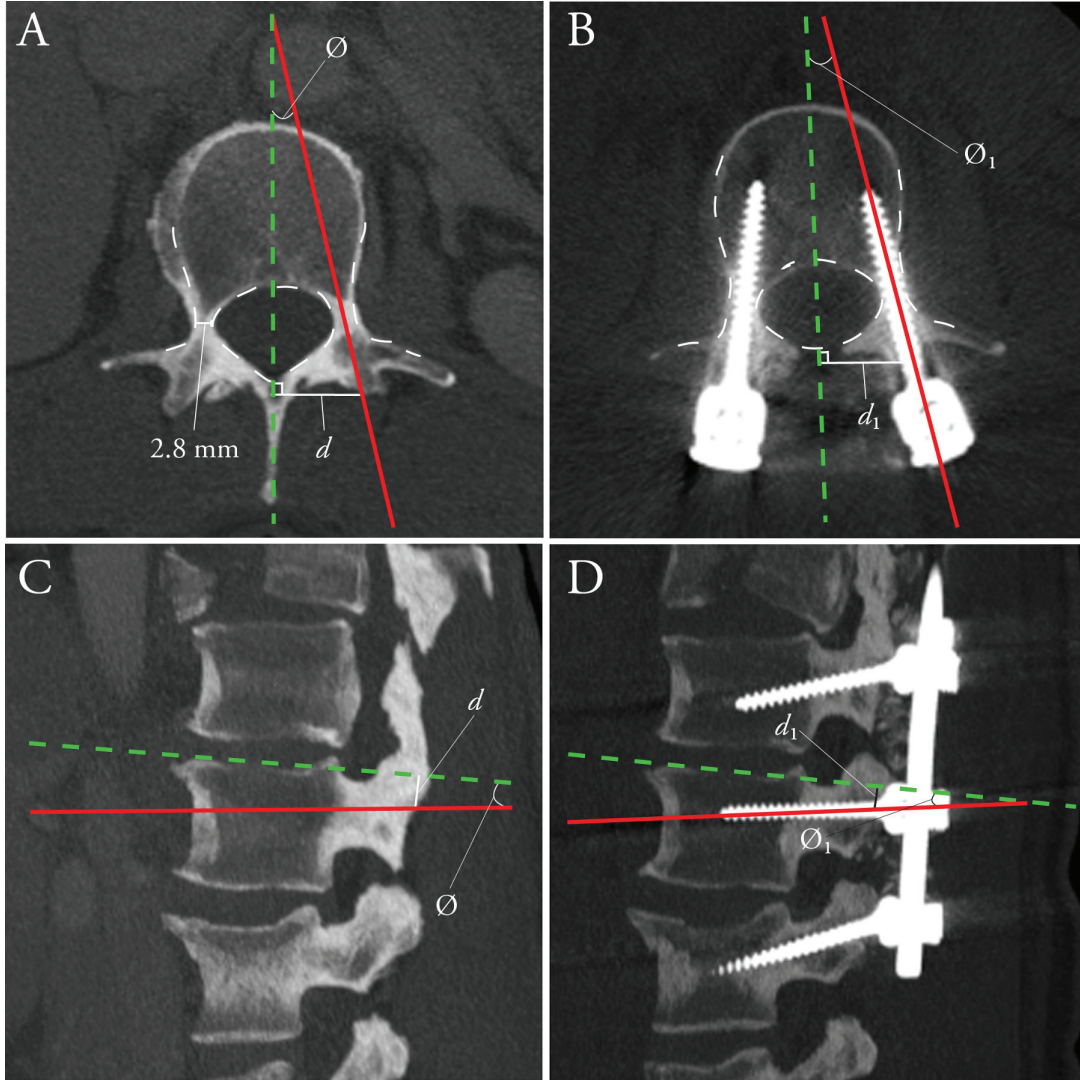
Engineering analysis quantifying absolute translational and angular deviation in the axial and sagittal planes. Example shown of a patient with hypoplastic pedicles at L2. A) Intraoperative predicted screw trajectory (red) as visualized on a pre-operative axial CT. B) Post-operative actual screw trajectory (red) as visualized on a multiplanar reformatted post-operative CT. Axial distances ( $d$ ) were measured at  $90^\circ$  relative to midsagittal axis (green line). Angle ( $\phi$ ) represents corresponding trajectory angles. C) Intraoperative predicted screw trajectory (red) as visualized on a pre-operative sagittal CT. D) Post-operative actual screw trajectory (red) as visualized on a multiplanar reformatted post-operative CT. Sagittal distances ( $d$ ) were measured at  $90^\circ$  relative to the inferior or superior sagittal endplate (green line). Angle ( $\phi$ ) represents corresponding trajectory angles. Errors in each plane were calculated as  $d_1 - d$  (translational) and  $\phi_1 - \phi$  (angular).
